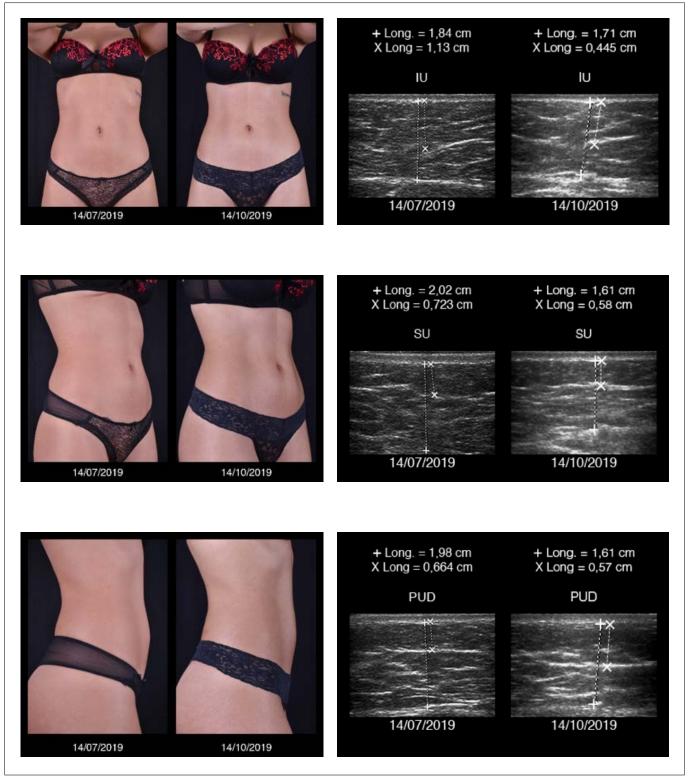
Reduction in the overall abdominal volume and an improvement in muscle tone correlating with variations in ultrasound studies in an anthropometrically normal patient.*
